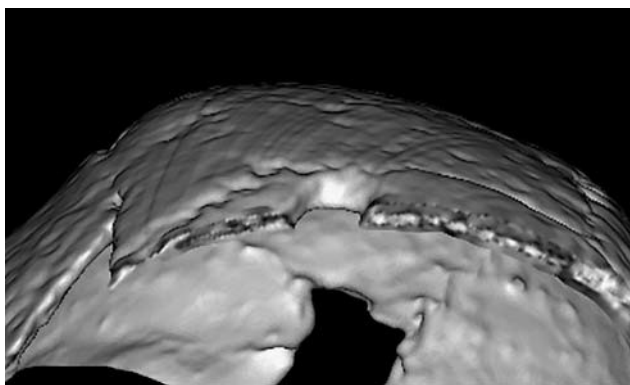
Volume rendering technique (VRT), coronal plane /virtual cut-off/, CT scan, Rudine (scan by M. Čavka).
